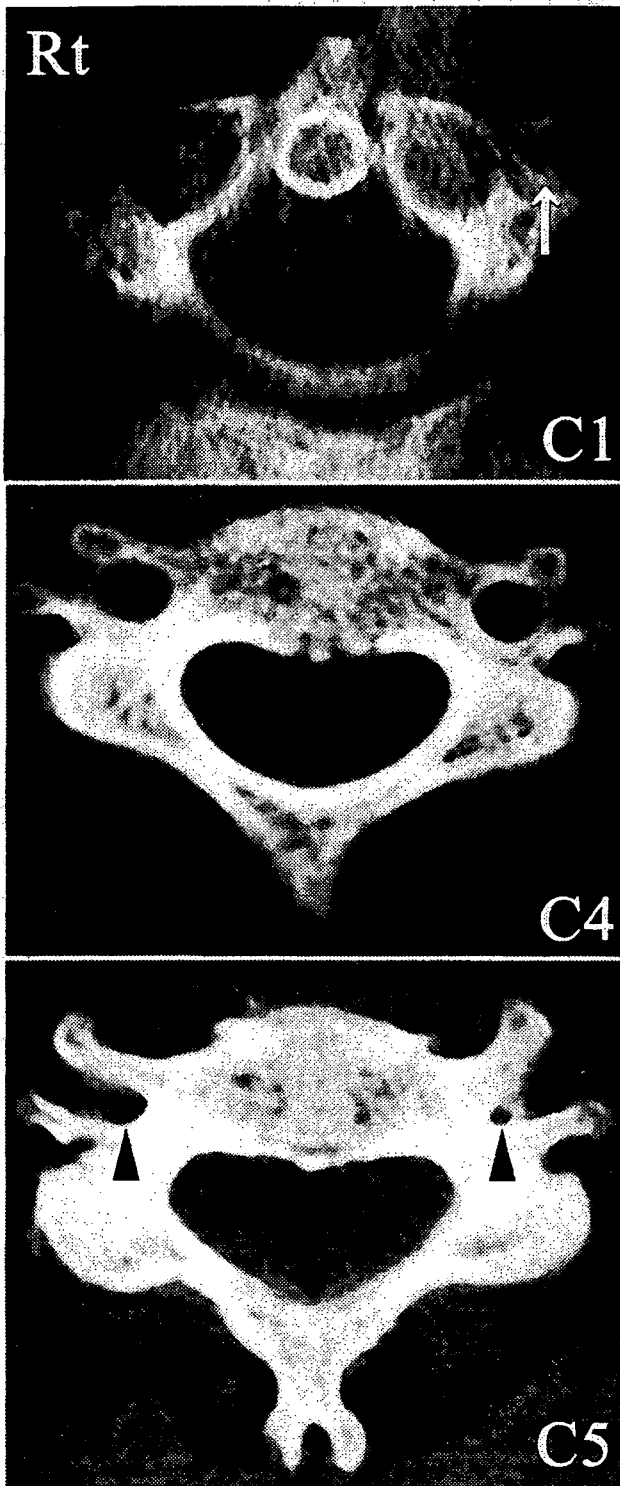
Axial CT scans acquired at the C-1 (upper), C-4 (center), and C-5 (lower) levels showing that the size of the transverse foramen was smaller at C-1 on the left side (arrow) and at C-5 on both the left and right sides (arrowheads).
